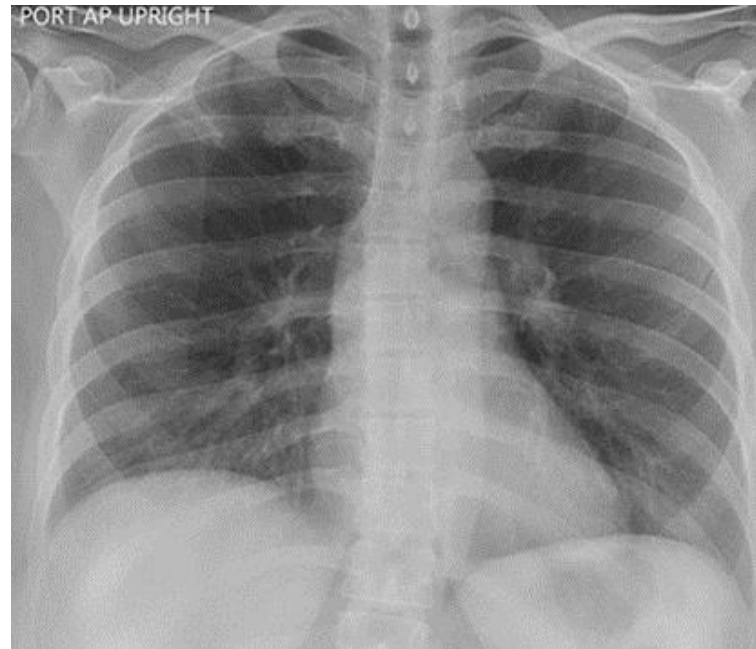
Initial frontal chest radiography. Which of the following represents an appropriate interpretation of her frontal chest radiograph?
